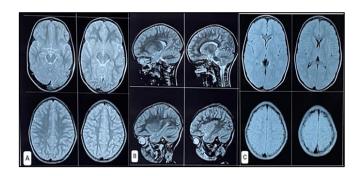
(A) Axial section and (B) Sagittal section T 2 weighted MRI images and (C) T2 flair showing normal brain.
